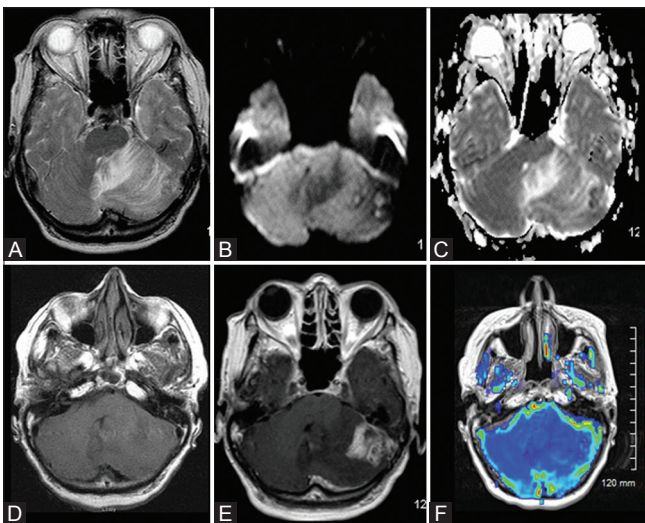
(A-F): MRI brain with contrast in case 2 shows vasogenic edema (A) in left cerebellar hemisphere surrounding an ill-defined altered signal intensity mass lesion demonstrating small focal areas of restricted diffusion (B and C). The mass lesion shows heterogeneous conglomerate ring enhancement (D and E). Contrast enhanced dynamic susceptibility imaging (DSC) MR perfusion with contrast (F) shows no evidence of increased perfusion/neoangiogenesis
